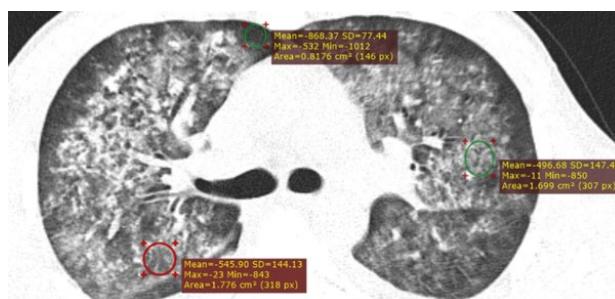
Results of computer tomography (CT) of chest cavity organs in axial projection of the deceased L. CT-signs of alveolar hemorrhage
